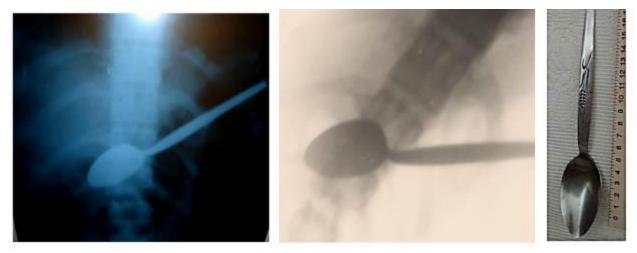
X-Ray Abdomen and fluoroscopic scan of a young adult female patient presented with spoon swallowing; The case is published by the corresponding author as a case report⁽¹⁾.
